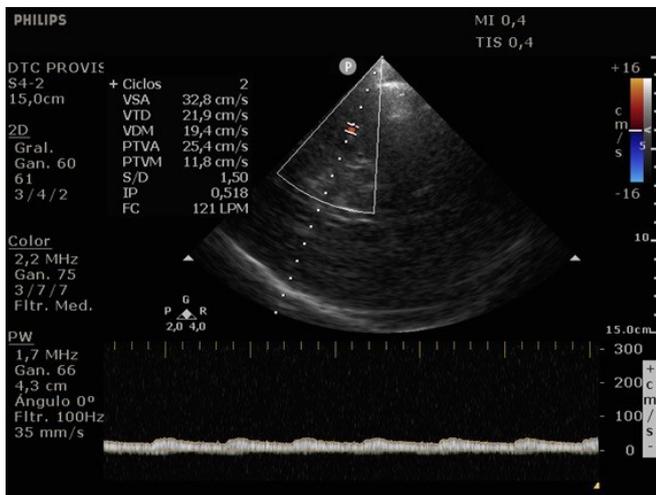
Transcranial ultrasonography of the distal middle cerebral artery.
